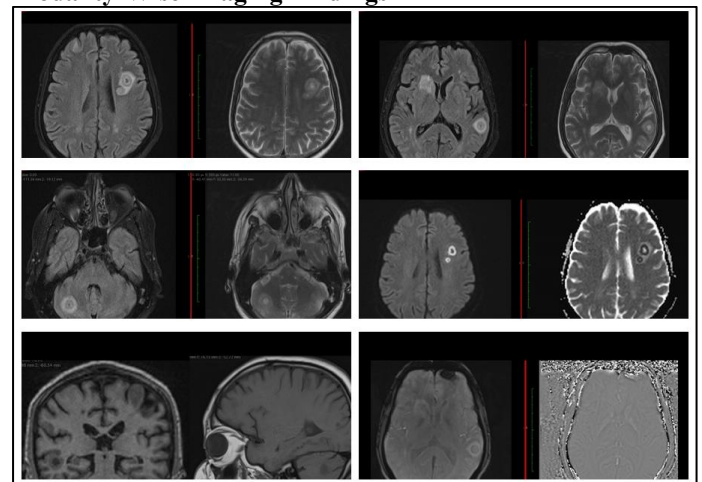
MRI brain images- multifocal cerebral/cerebellar ring and nodular lesions on FLAIR/T2/DWI/ADC/SWI/T1 images
